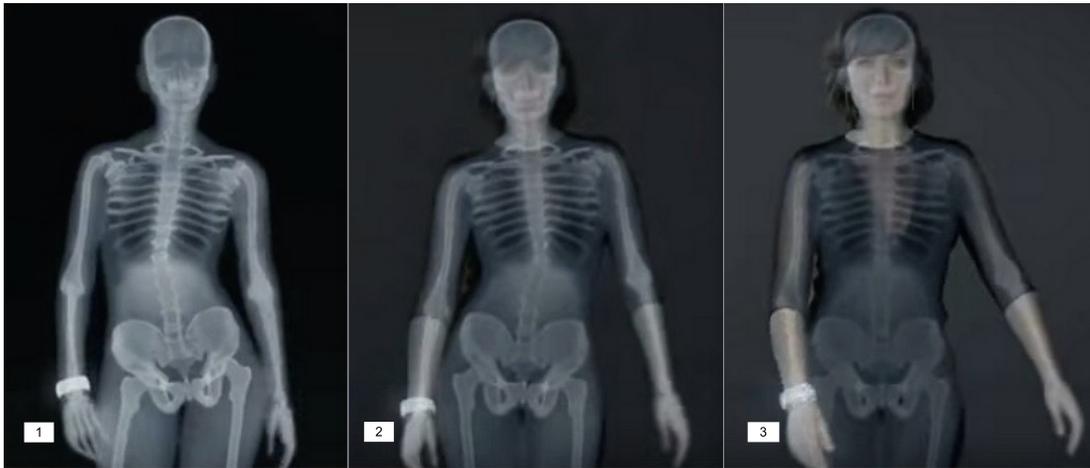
X-ray vision of the spinal engine at work: frame 1 weight on right, stepping forward on left, thoracic rotation to left zeroing out lumbar rotation to right at about T12/L1; frame 2, steps changed; frame 3, spinal curvatures in about same sagittal plane in neutral.
